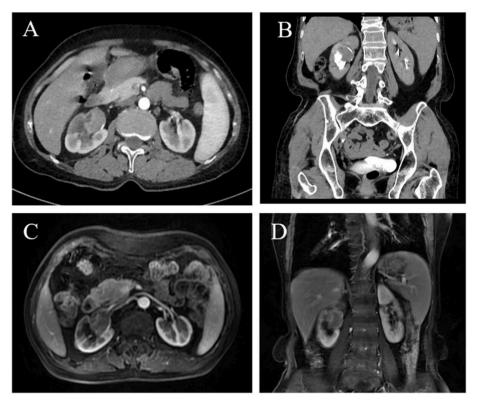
Imaging manifestations of Sarcomatoid renal pelvis carcinoma. A-B) CT suggests a low-density soft tissue mass in the right renal pelvis with clear borders and uniform moderate enhancement. It was accompanied by mild hydronephrosis of the right renal calyx. C-D) MRI of the kidney showed an irregular TI isosignal, T2 isosignal mass, about 2.4*3.2cm in size, with obvious high signal in DWI diffusion restriction, obvious low signal in ADC, mild enhancement in enhancement scan, unclear boundary of the lesion, involving the renal sinusoids and lateral renal parenchyma.
